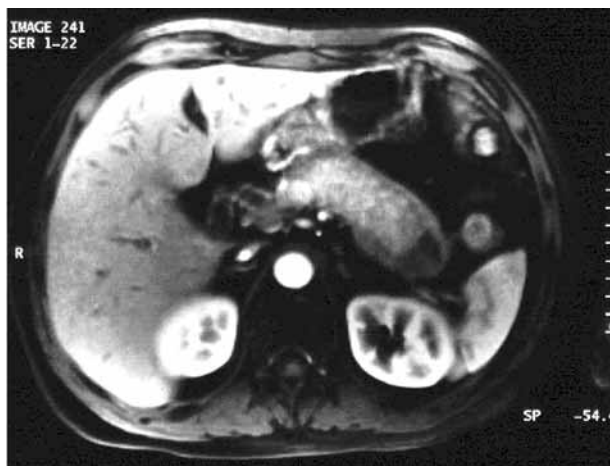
MRI showing diffuse swelling of the pancreas, surrounded by a hyporeflective rim on T1 weighted images. This is pathognomonic for autoimmune pancreatitis. There is a small fluid collection in the pancreatic tail (arrow).
